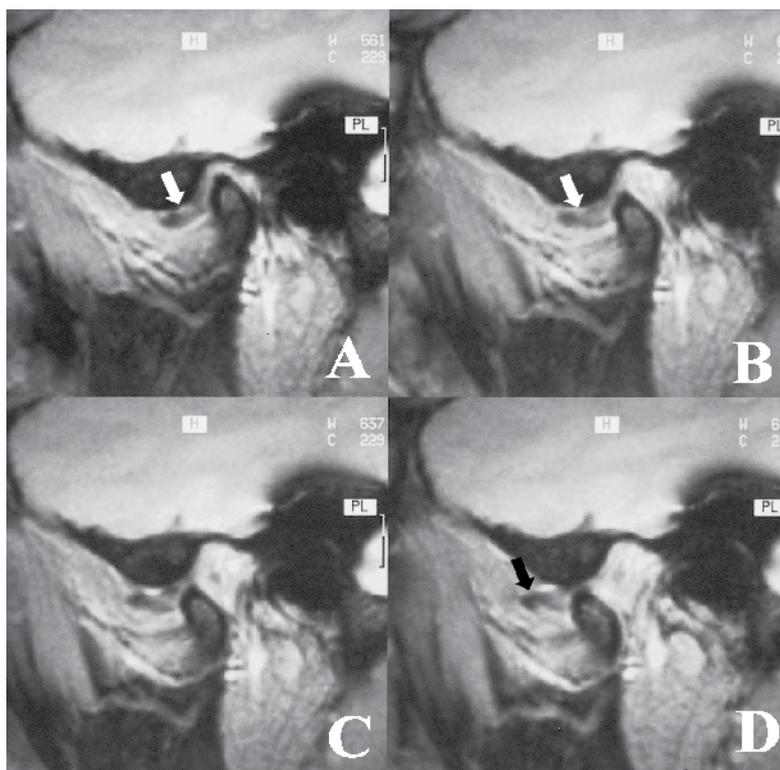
MRI of TMJ arthritis with articular effusion (sagittal section)
